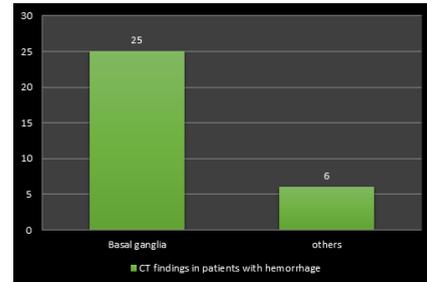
CT findings in patients with hemorrhage
